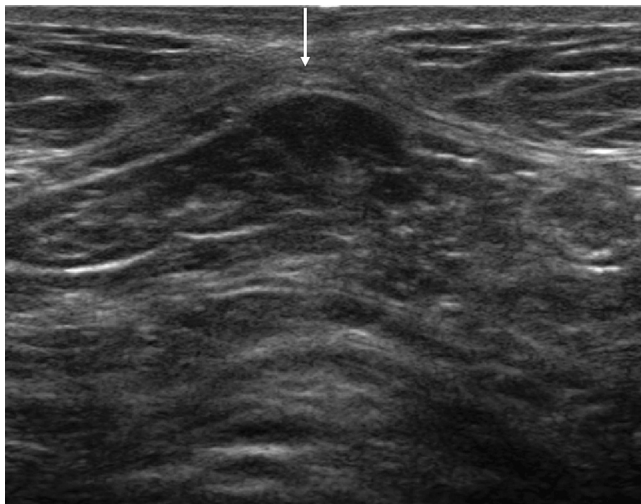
Divarication of rectus abdominis muscles. The midline transverse sonography, showing a defect of the linea alba (arrow), which resulted in separation of the rectus muscles (divaricate) and anterior bulging of the underlying peritoneal cavity.
